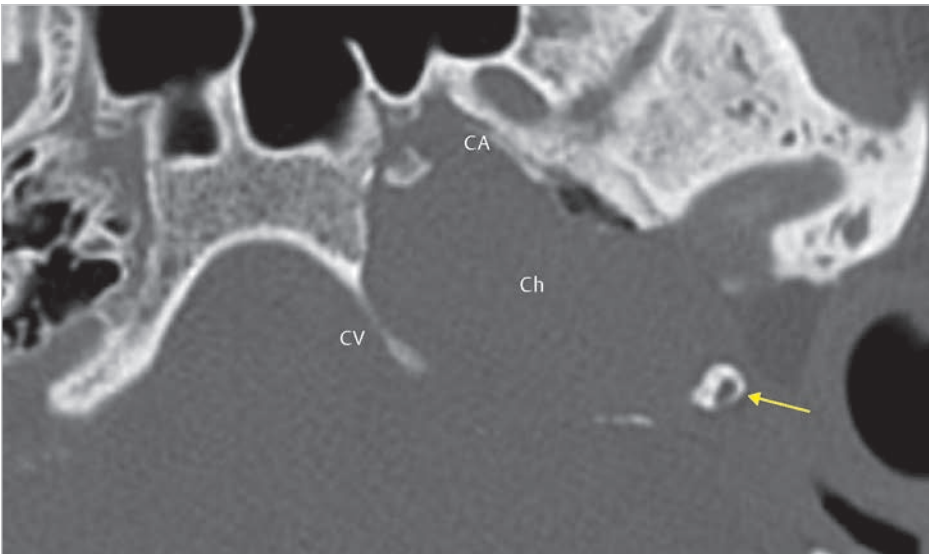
The patient underwent surgery four times elsewhere including middle fossa approach with no radical removal of cholesteatoma. The axial CT demonstrates presence of a massive round-shaped mass in the petrous apex. The majority of structures in the temporal bone is disappeared except the fallopian canal (*arrow*). CA, carotid artery; Ch, cholesteatoma; CV, clivus.
